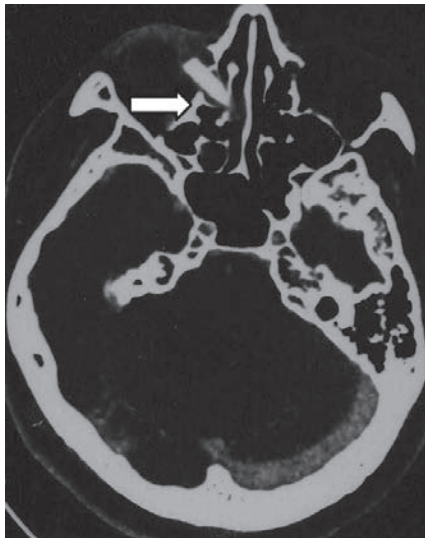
CT shows a radio-opaque rod-like foreign body (arrow) extending from the medial wall of the right orbit, traversing the ethmoidal sinuses to the apex of the left orbit.
